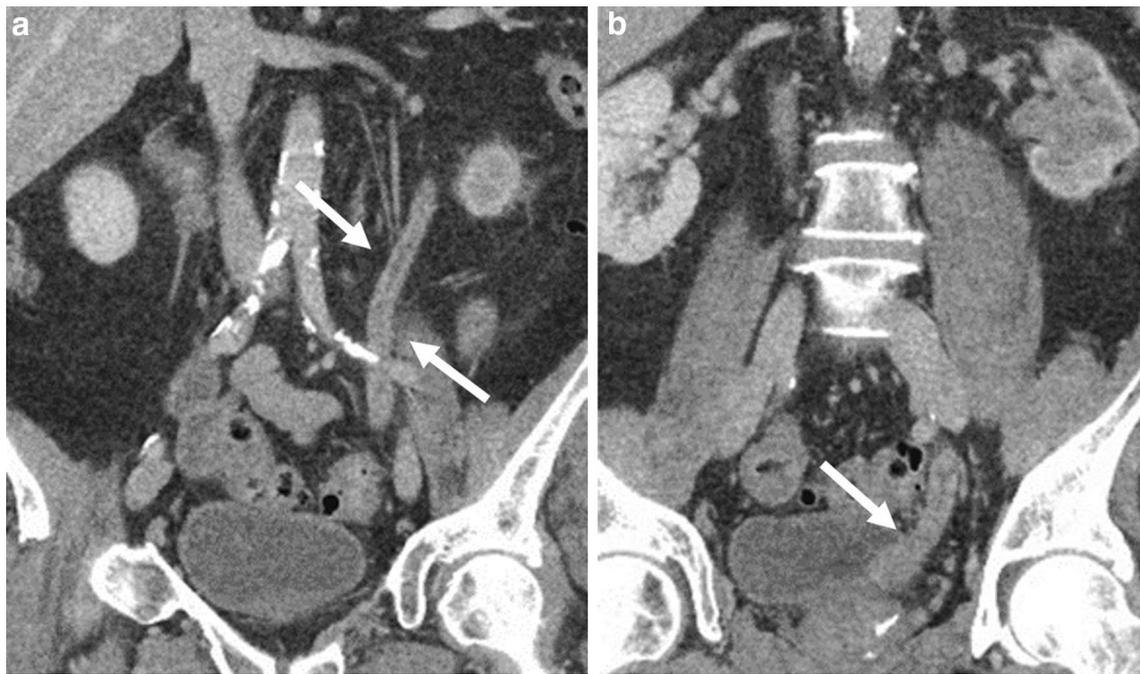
CT urogram obtained during the nephrographic phase (a, b) demonstrated diffuse urothelial thickening involving the entire left ureter and left renal pelvis (arrows) consistent with urothelial carcinoma
